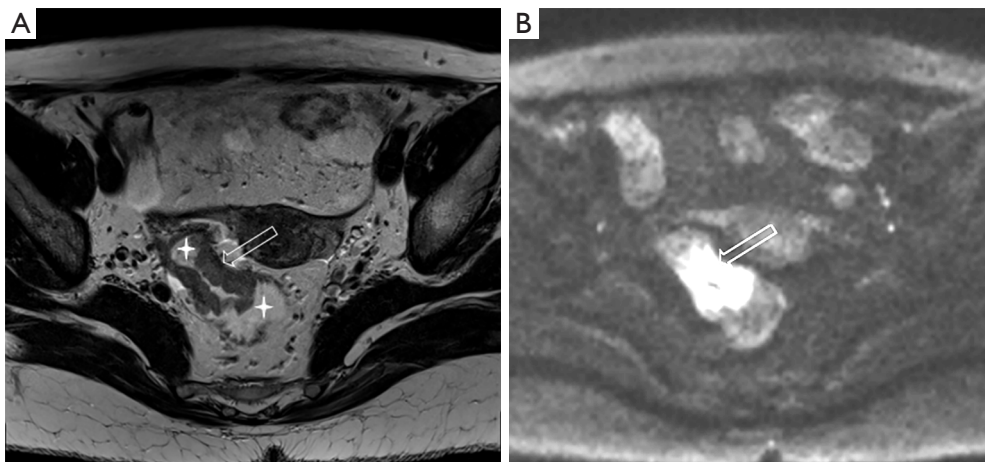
A 54-year-old man with high RC. (A) Axial MR rectography shows the tumor (arrow) and the well filled rectum (asterisk); (B) axial DWI demonstrates the tumor (arrow) with clarity. RC, rectal cancer; DWI, diffusion weighted imaging.
